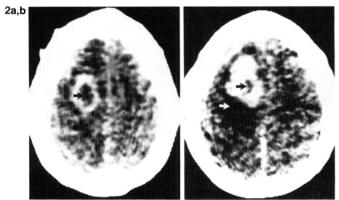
Postcontrast axial CT scans 15 (a) and 32 (b) days after inoculation. A dense, irregular mass with central lucency (black arrows) is detected. The mass has increased from 11.3×17.3 to 15.4×22.7 mm during the 17 follow-up days. Perifocal edema area (white arrow, b) and midline shift are also increased at 32 days.
